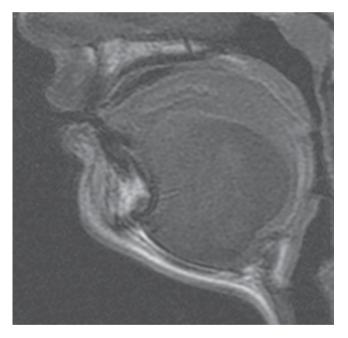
T-1-weighted sagittal MRI of lingual dermoid cyst
